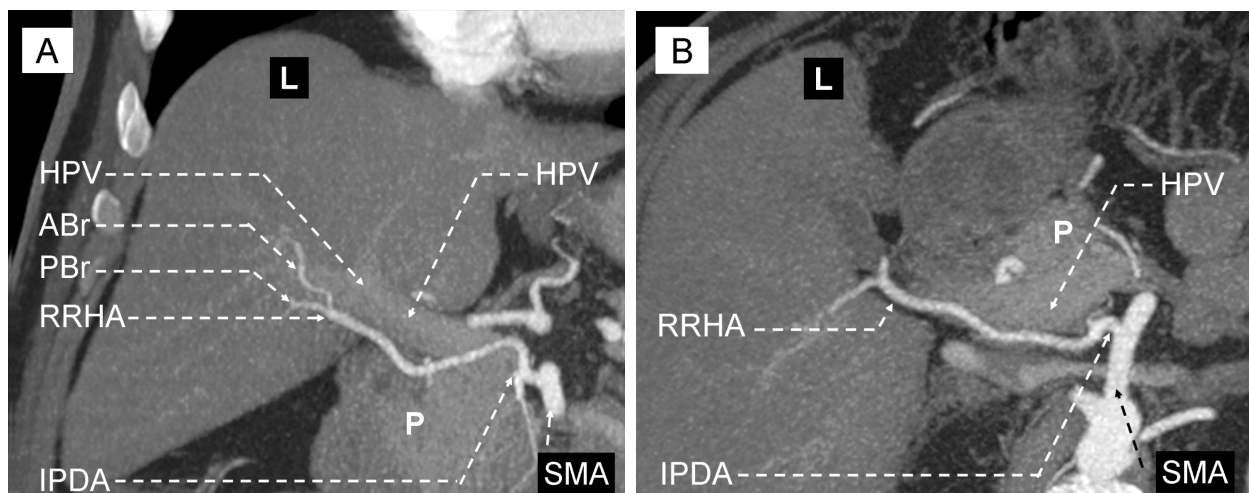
MDCT angiography of the liver. MIP image shows the superior mesenteric artery and replaced right hepatic artery: (A) Coronal image; (B) Transversal image. MDCT: Multidetector computed tomography; MIP: Maximum intensity projection; L: liver; P: Head of pancreas; HPV: Hepatic portal vein; SMA: Superior mesenteric artery; IPDA: Inferior pancreaticoduodenal artery; RRHA: Replaced right hepatic artery; ABr: Anterior branch; PBr: Posterior branch.
